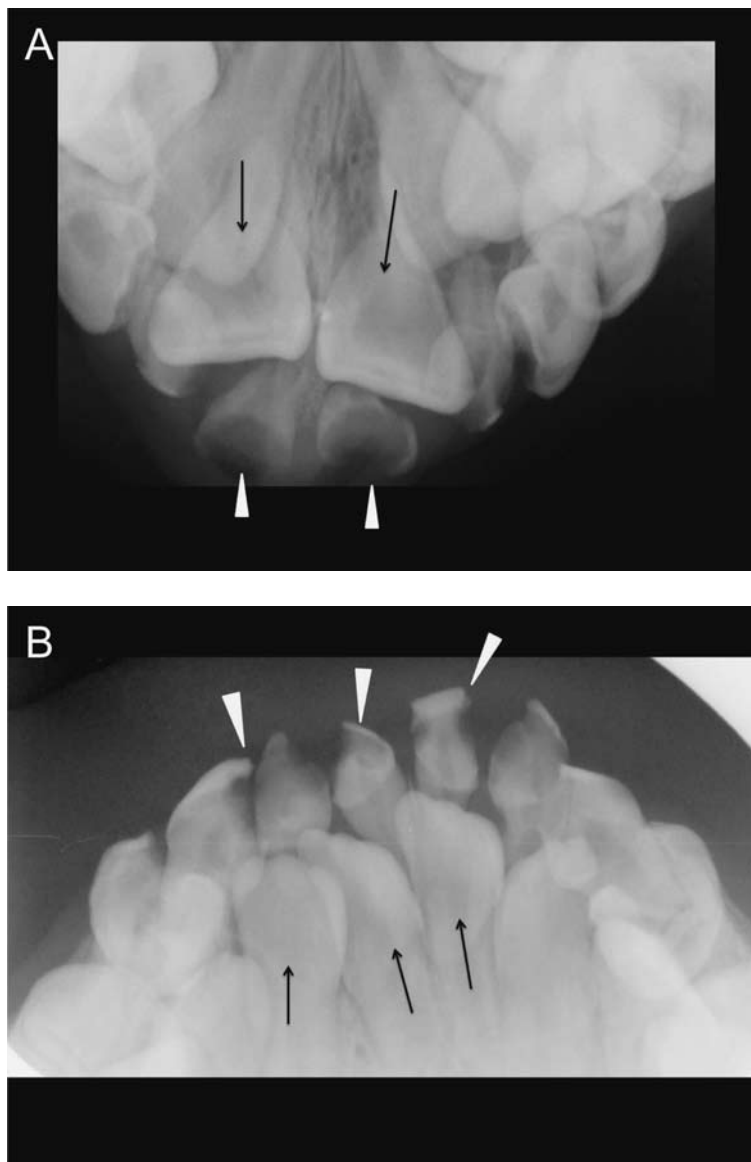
Dental X-rays of the maxillary teeth (A) and mandibular teeth (B) show dental crowding and double rows of teeth with permanent teeth (arrows) erupted lingual to the deciduous teeth (arrowheads).
